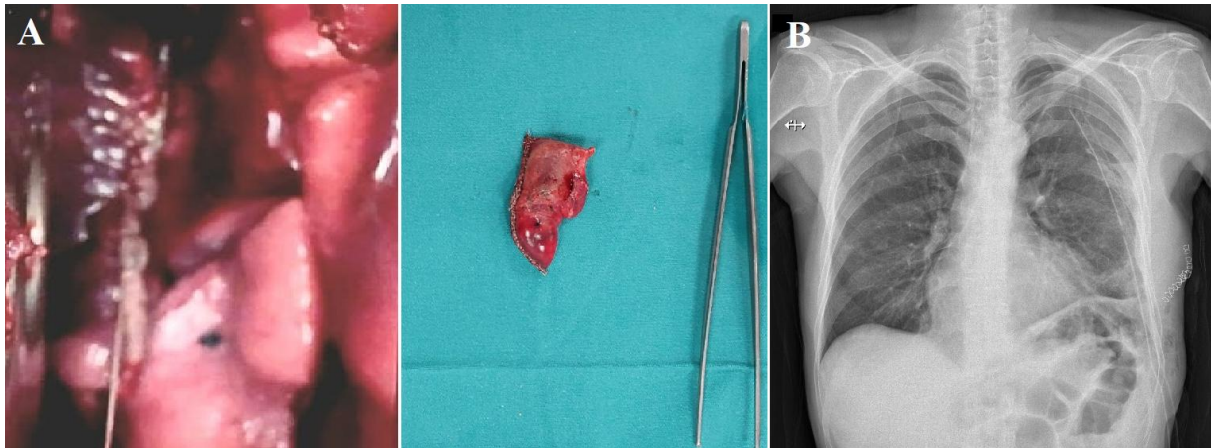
A. Images of exploration of the thorax and nodular lesion B. Postoperative chest X-ray
